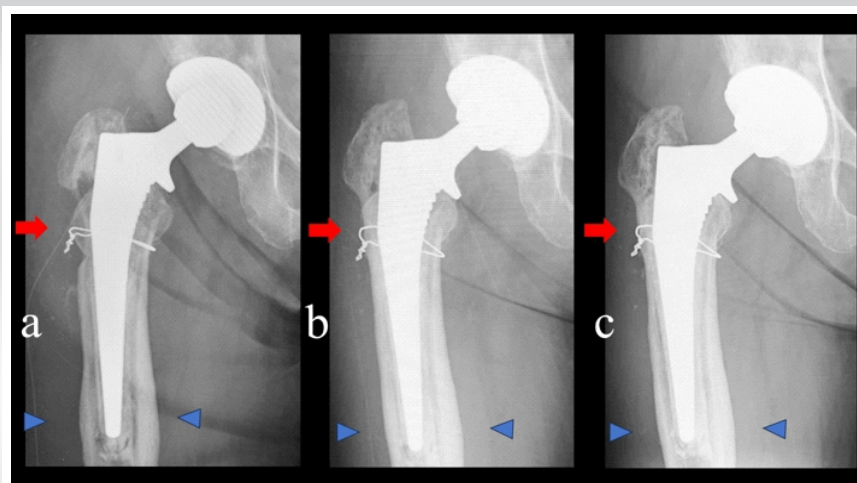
Bone growth and remodeling on X-ray images in Case 2. (a) X-ray after revision total hip arthroplasty. A stem revision surgery was performed using a combination of IBG and a collared fully hydroxyapatite-coated stem. The morselized allograft bone and bulk bone grafting were performed at the lateral defect of the greater trochanter (red arrow). (b) X-ray 1 year postoperatively. The stem had subsided by 3 mm, but the grafted bulk bone showed signs of remodeling (red arrow). (c) X-ray 3 years postoperatively. The allograft bone at the greater trochanter had integrated, making the boundary with the host bone indistinct (red arrow). Cortical hypertrophy at the distal stem had not progressed (blue arrowhead).
